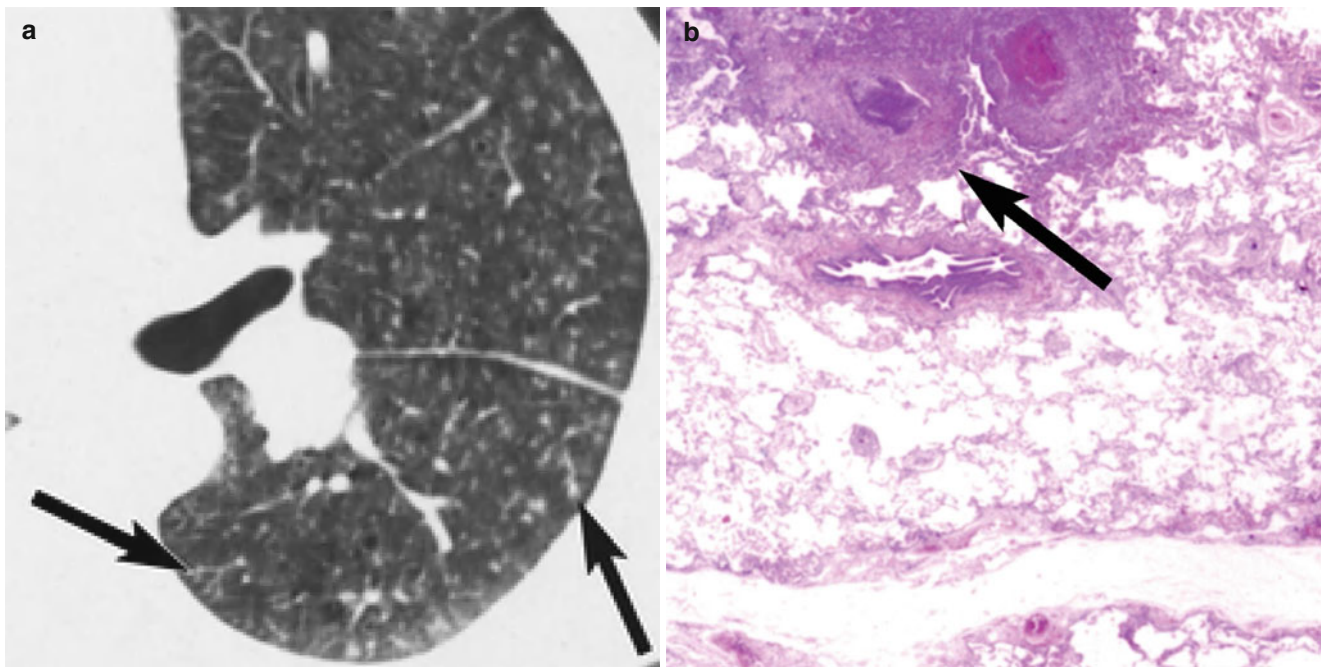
Cellulose granulomatosis (foreign-body-induced pulmonary vasculitis) in a 37-year-old man who is a drug abuser. (a) Thin-section (1.5-mm collimation) CT scan obtained at level of left interlobar pulmonary artery shows diffuse pulmonary involvement with ill-defined centrilobular
